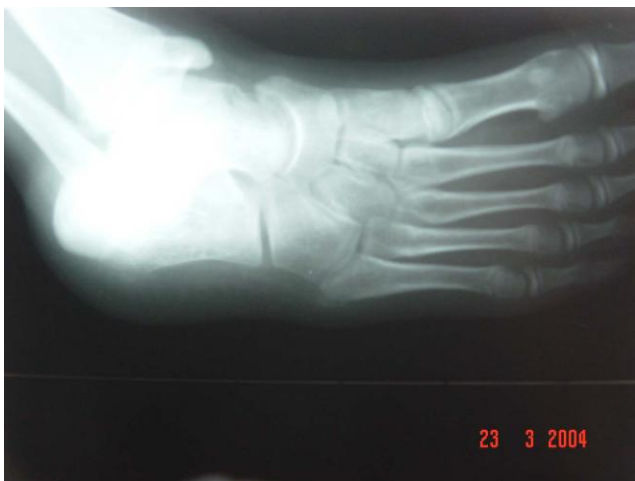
X-Ray of a 12 years old girl with typical finding of avulsed bone from the base of the metatarsal.
